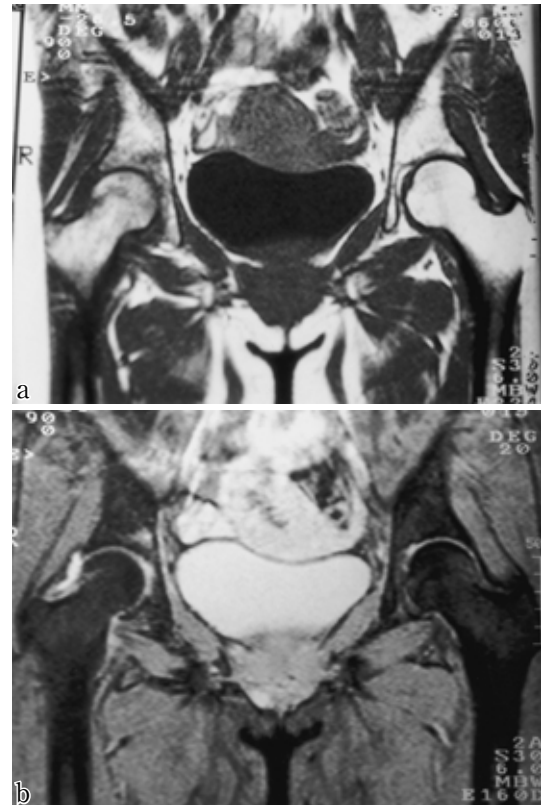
MRI findings at 14 weeks after onset (case 1)
